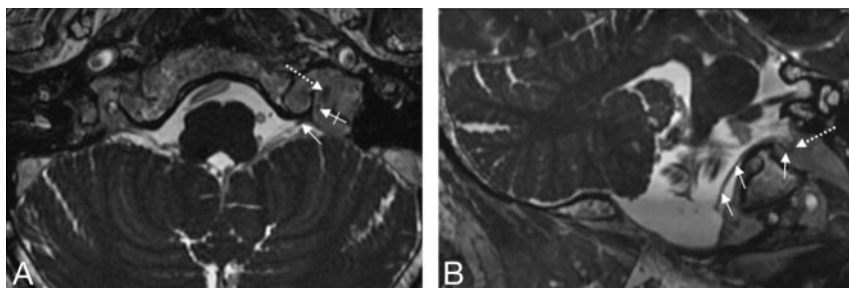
A* and *B*, Depiction of the spCNXI on FIESTA MR imaging. The spCNXI (*thin white arrows*) is visualized on axial (*A*) and oblique coronal (*B*) FIESTA MR images in its cisternal course (*thin arrows*) and after its entrance into the JF (*crossed arrow*). The *dotted arrow* indicates the CNX/XI complex.
